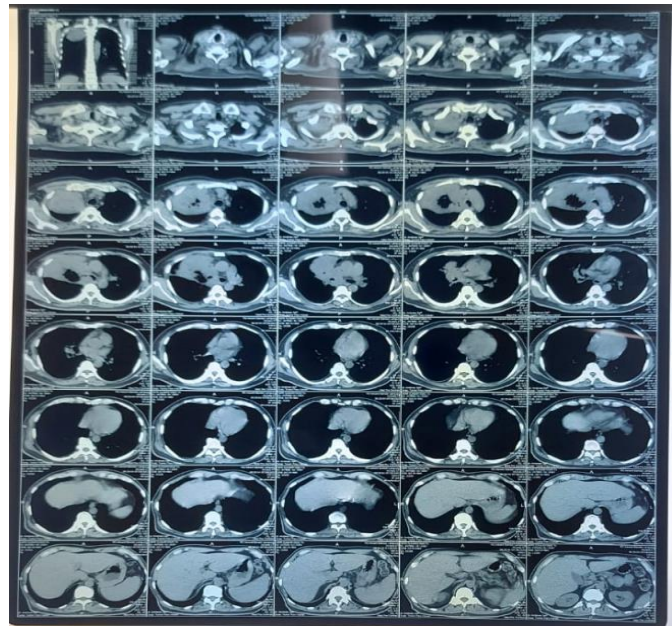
A stable condition Thorax CT Scan with kontras
